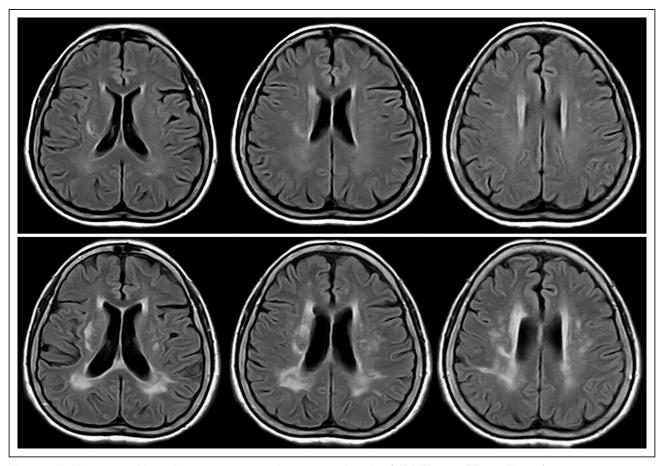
Fluid-attenuated inversion recovery magnetic resonance imaging (MRI; TR 9000, TE 120, TI 2500).
